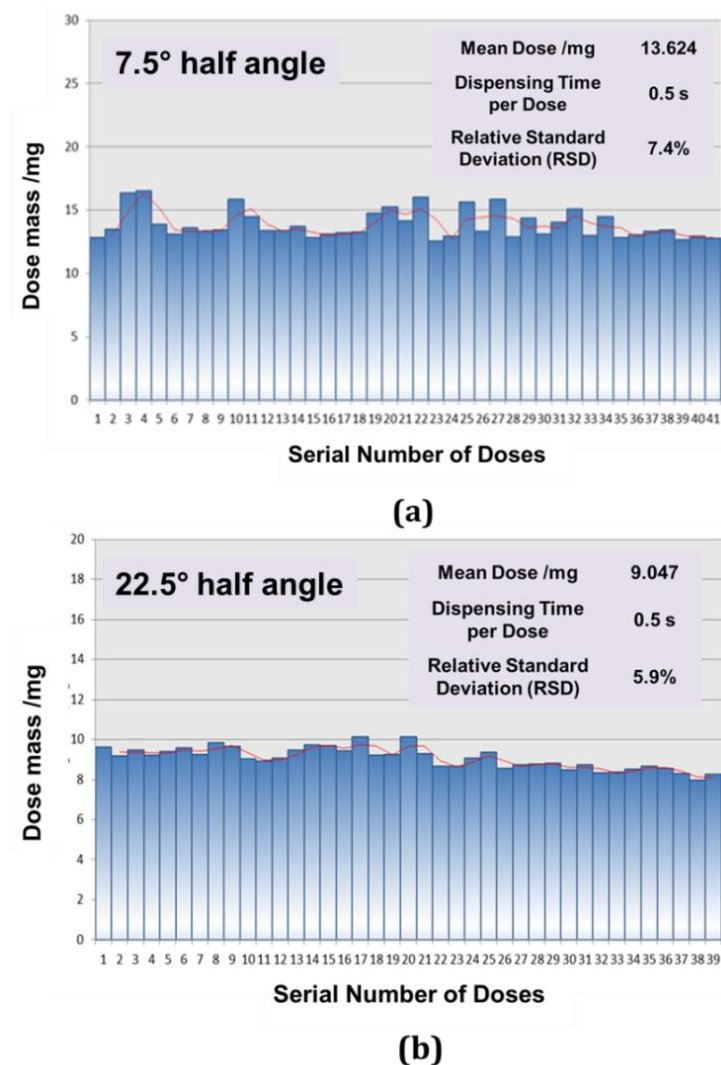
5 Evaluation chart of ultrasonic dispensing of lactose Inhalac® 70 with half conical angle (a) 7.5° and (b) 22.5°. Orifice size is 0.8 mm and duration of vibration is 0.5s
